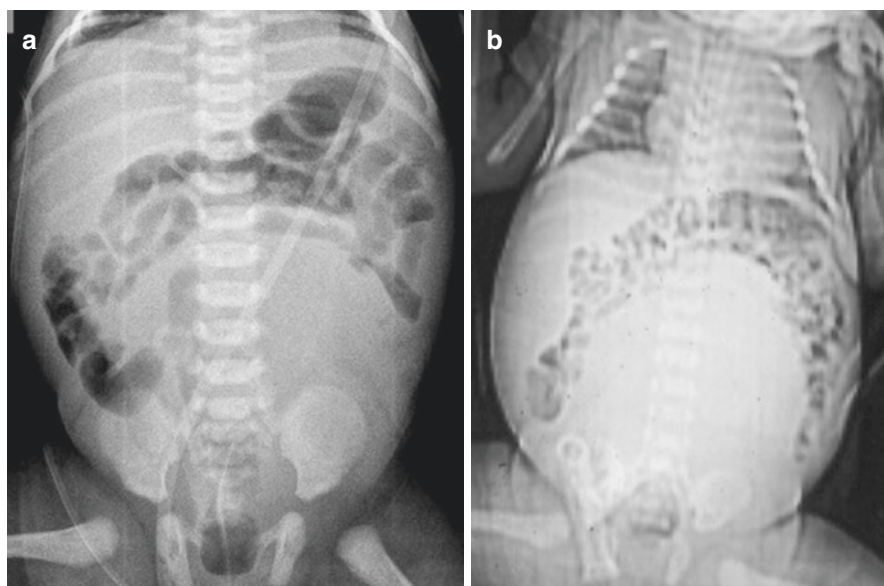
(a and b) Abdominal radiograph showing a soft tissue density pushing the bowel upwards and to the sides. This soft tissue represents hydrometrocolpos secondary to vaginal atresia
